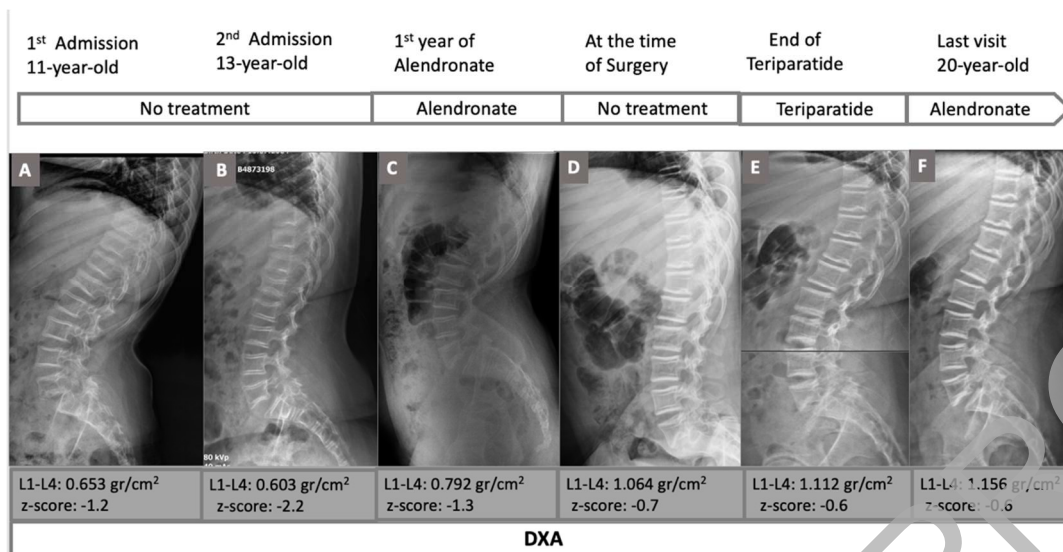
Lateral vertebra radiographs and bone mineral density (BMD) measurements by DXA in the patient, showing progression of the vertebra compression fractures and a decline in BMD over a 2-year untreated period (A, B). Improvement in BMD is observed after 1 year of alendronate treatment (C), followed by complete reshaping of the vertebral bodies and restoration of BMD at the time of surgery (D, age 16.5 year) and during subsequent follow-up
